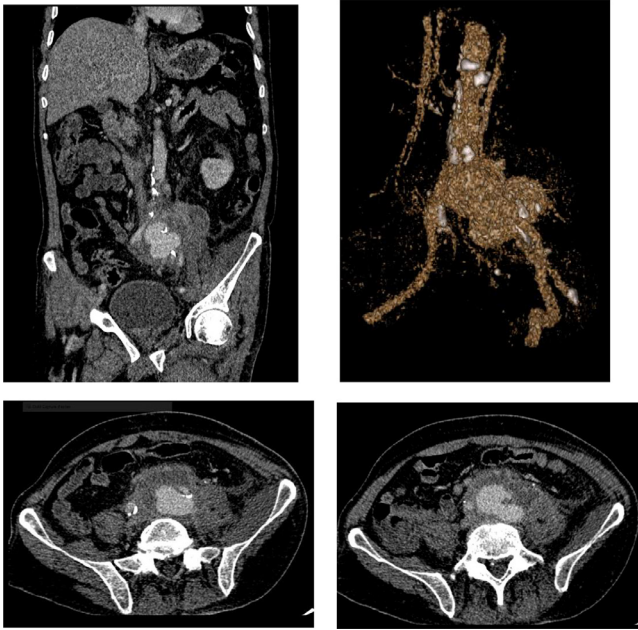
Contrast-enhanced computed tomography scan obtained at admission shows a 27 mm left common iliac artery pseudo-aneurysm with a 5 mm proximal neck, with an irregular lumen, which was contiguous with a left psoas muscle abscess, pelvic external iliac and left obturator adenopathy, and ipsilateral uretero-hydronephrosis.
